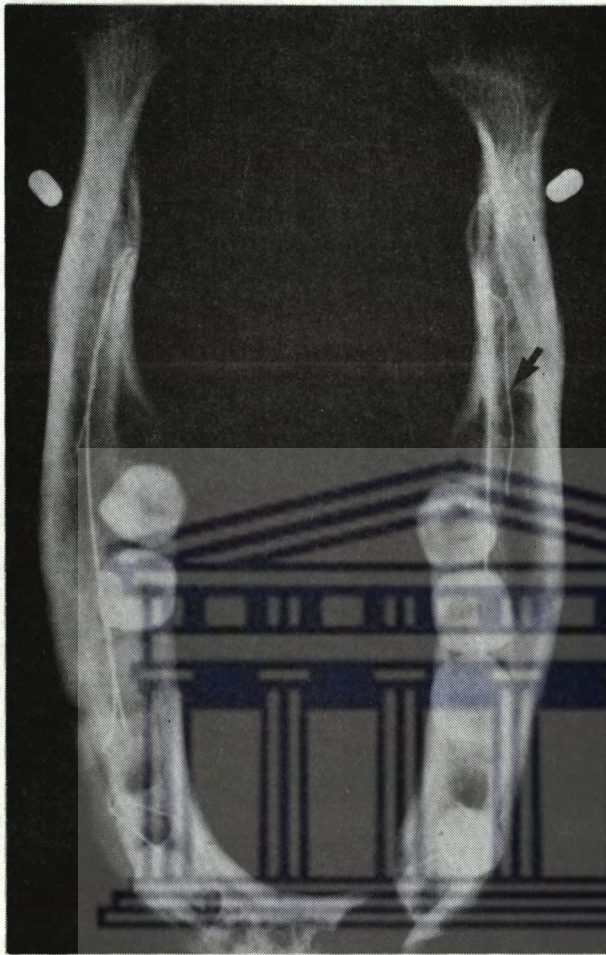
A radiograph of the mandible in the vertical position. The right side shows the mandibular canal lying buccally to the last molar tooth. On the same side, the accessory canal, leading off the mandibular canal, appears to lie superimposed on the mandibular canal whereas on the left side it is not (arrow).
